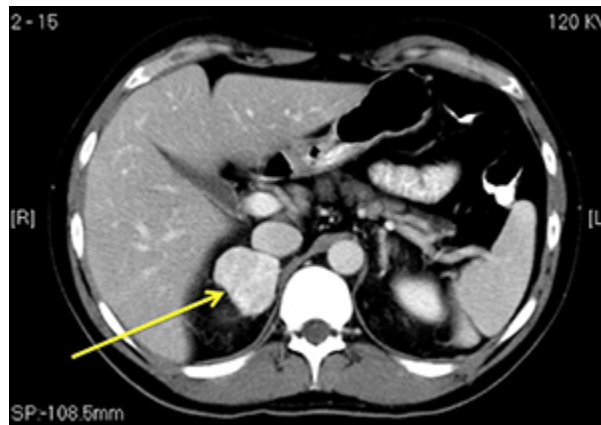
CT scan demonstrating a right adrenal mass (arrow).
